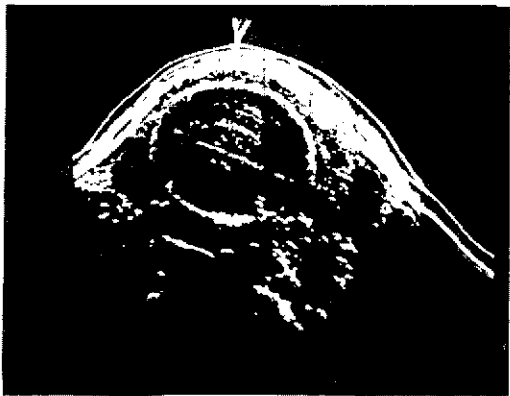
A-mode (right) and B-mode sonograms of fetal head. At or near term, biparietal diameter can be measured equally well from either mode.
